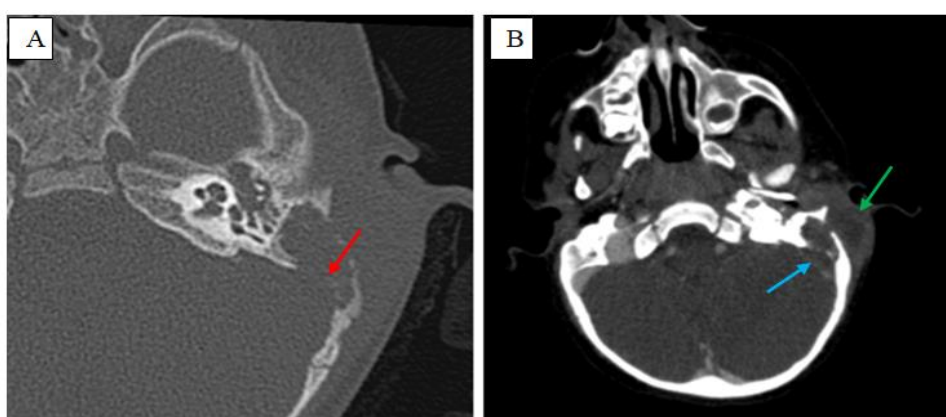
CT scan of temporal bone in axial section (A) and brain CT scan with contrast enhancement showed destruction of left sigmoid sinus plate (red arrow) with sinus thrombosis (blue arrow). It's associated with a collection of soft parts with peripheral enhancement after contrast application (green arrow)
